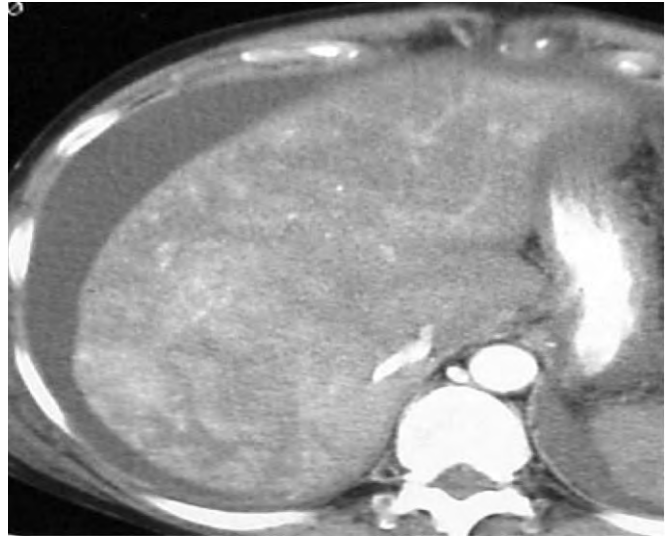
CT image of a patient with Budd-Chiari syndrome characterized by heterogeneously appearing hepatic parenchyma, caudate lobe enlargement, ascites, and no visualization of the hepatic veins.
